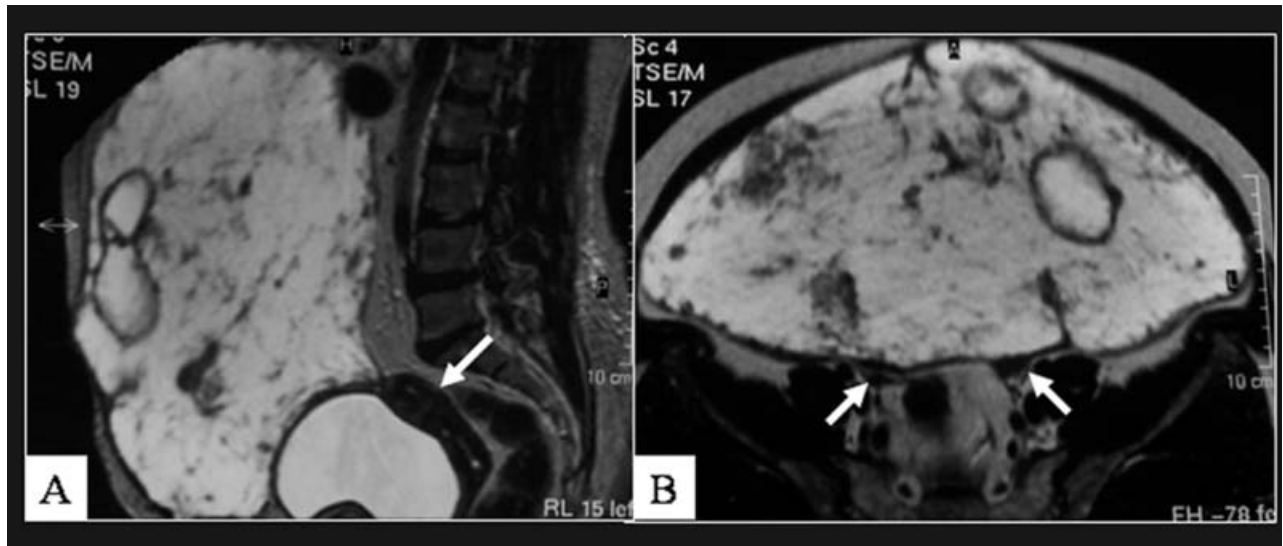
A. Sagittal T2-weighted image shows the tumor superiorly to the urinary bladder and uterus (arrow). B. Axial T2-weighted image shows right and left ovaries (arrows)
